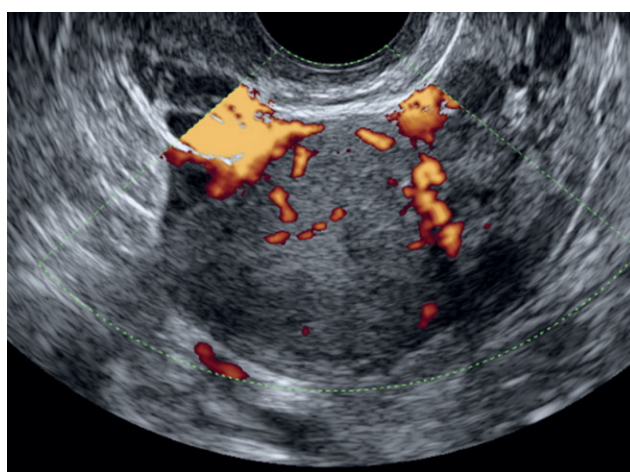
Power Doppler ultrasound image of ovarian metastasis from lung adenocarcinoma, showing moderate vascularization (color score, 3).
